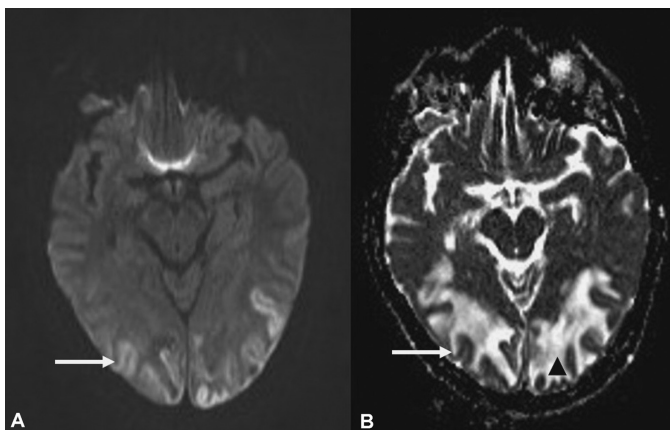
Atypical PRES. A: This b1000 DWI sequence shows posterior parietal and occipital cortical ribbon hyperintense signal (*arrow*). B: Corresponding ADC hypointensity (*arrow*). Additional confluent subcortical white matter hyperintense signal (*black arrowhead*, left occipital lobe) from T2 shine secondary to vasogenic edema.
